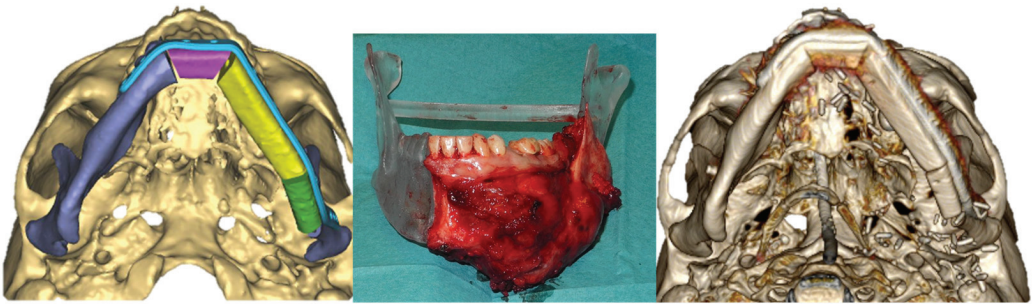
Mandibular resection inserted in the 3D printed model to verify the accuracy of the CAD-CAM guided presurgical planning and postoperative CT scan.
